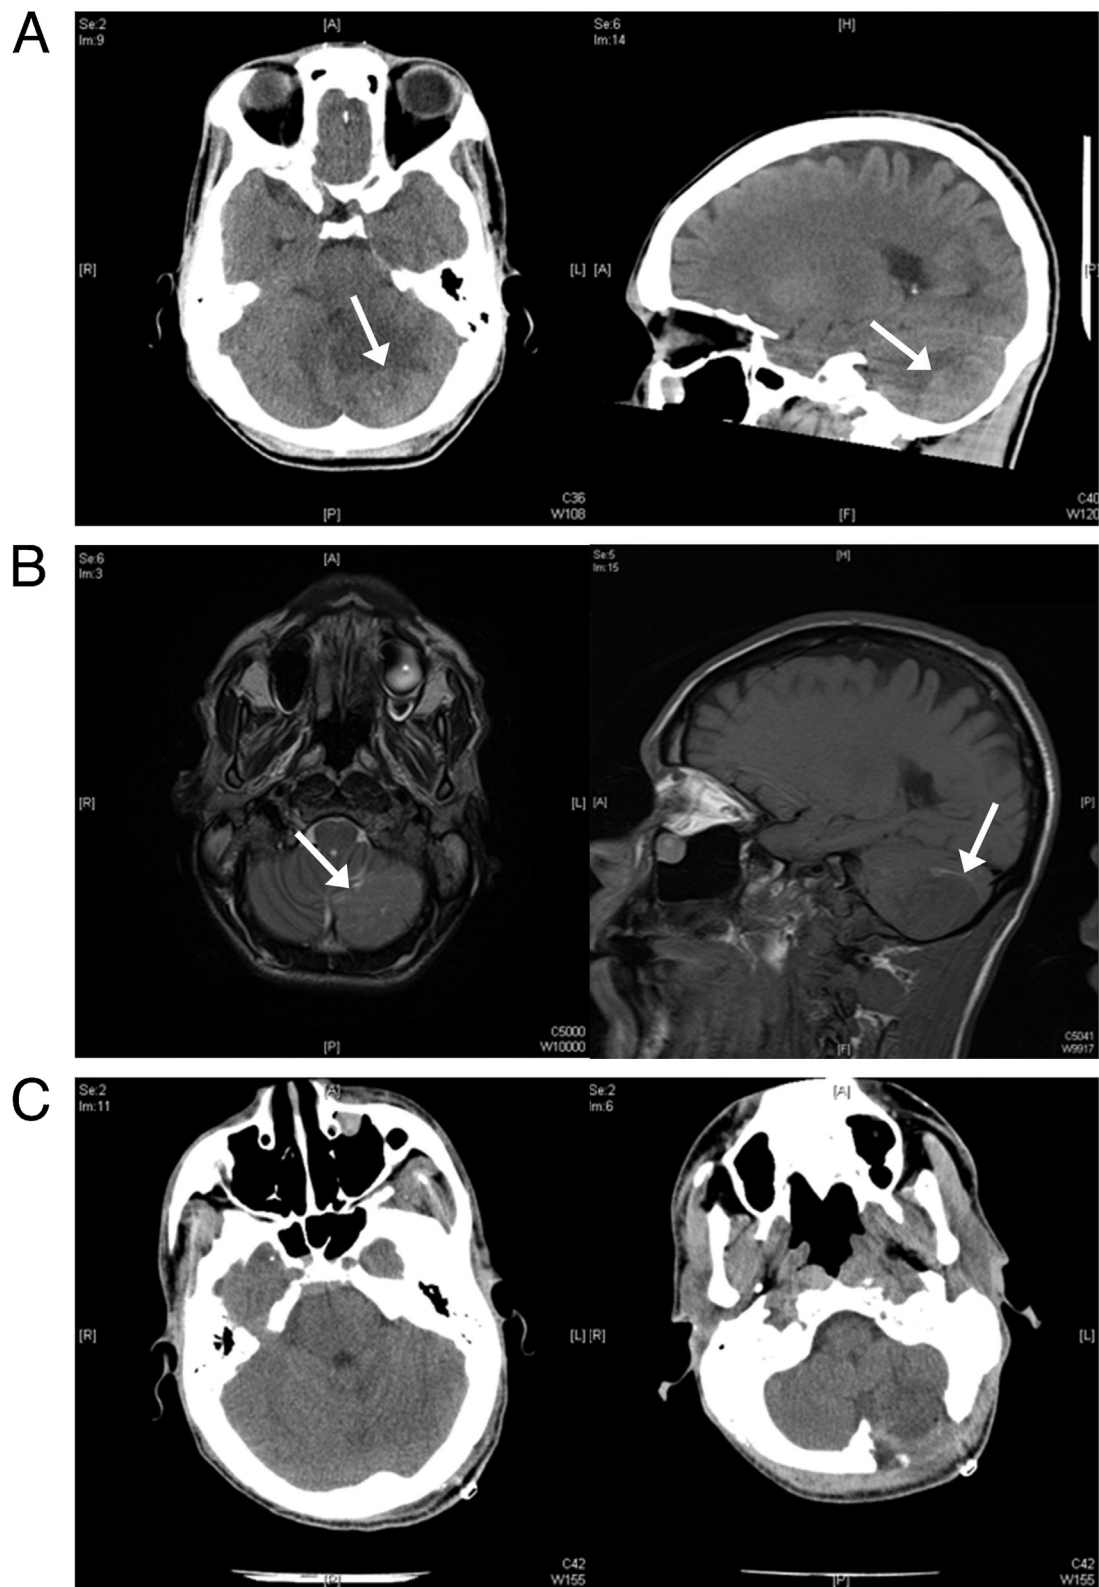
Preoperative axial and sagittal non-contrast computed tomography (CT) imaging demonstrates an expansile hyperdense lesion in the left cerebellar hemisphere (arrows). Fourth ventricle compression is apparent on axial CT (A). Preoperative axial (T_2 -weighted) and sagittal (T_1 -weighted) non-contrast magnetic resonance imaging (MRI) demonstrates a hyper- to isointense (T_2 -weighted) and hypointense (T_1 -weighted) heterogeneous lesion in the left cerebellar hemisphere (arrows) without apparent dural involvement (B). Postoperative axial non-contrast computed tomography (CT) imaging of the brain demonstrates cerebellar hemispheric symmetry and a normal decompressed fourth ventricle, as well as craniectomy site (arrow). The lesion seen preoperatively is no longer visible (C).
